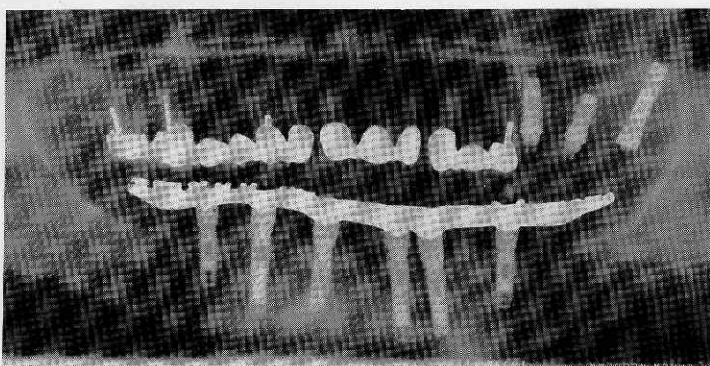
Panoramic radiograph 14 months after surgery showing osseous fill of the surgical defect.
